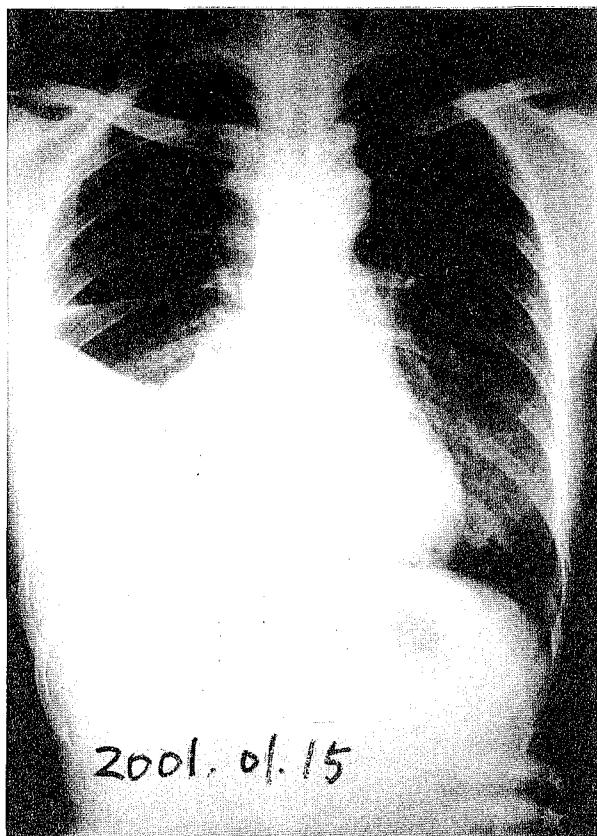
Chest radiograph only shows interstitial infiltration in the bilateral lower lung fields, right pleural effusion, and haziness in the lower right lung.
